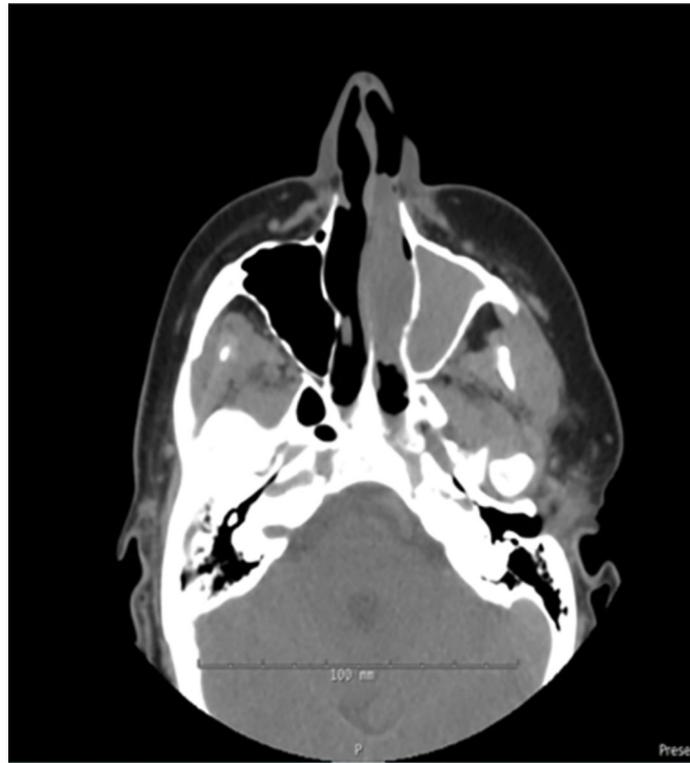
Axial CT image showing an enhancing soft tissue lesion involving the left nasal cavity with extension into the maxillary, frontal and ethmoid sinuses, abutting the orbit and base of skull.
